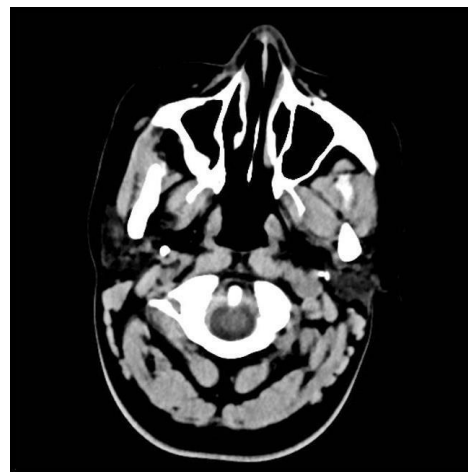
CT scan of a normal brain without stroke symptoms.
